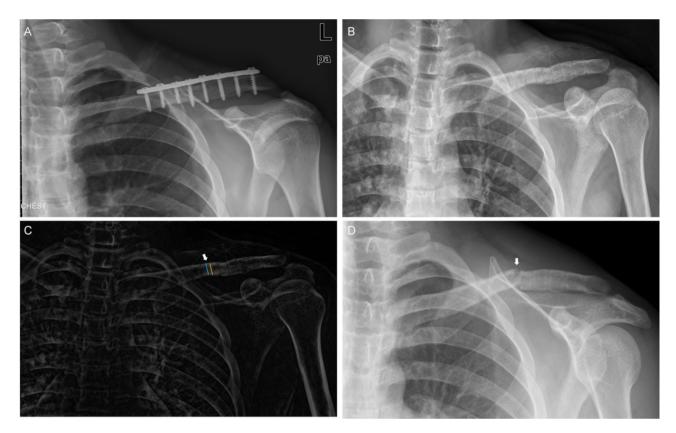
Measurement method of mean gray value of screw hole. A: preoperative X-ray of patient. B. postoperative X-ray of patient. C: Images were treated using Image J software, mean gray value of screw holes (yellow line) and marginal normal bone tissue (blue line) were measured by "straight or freehand line" measurements. D: refracture at the screw hole (white arrow)
